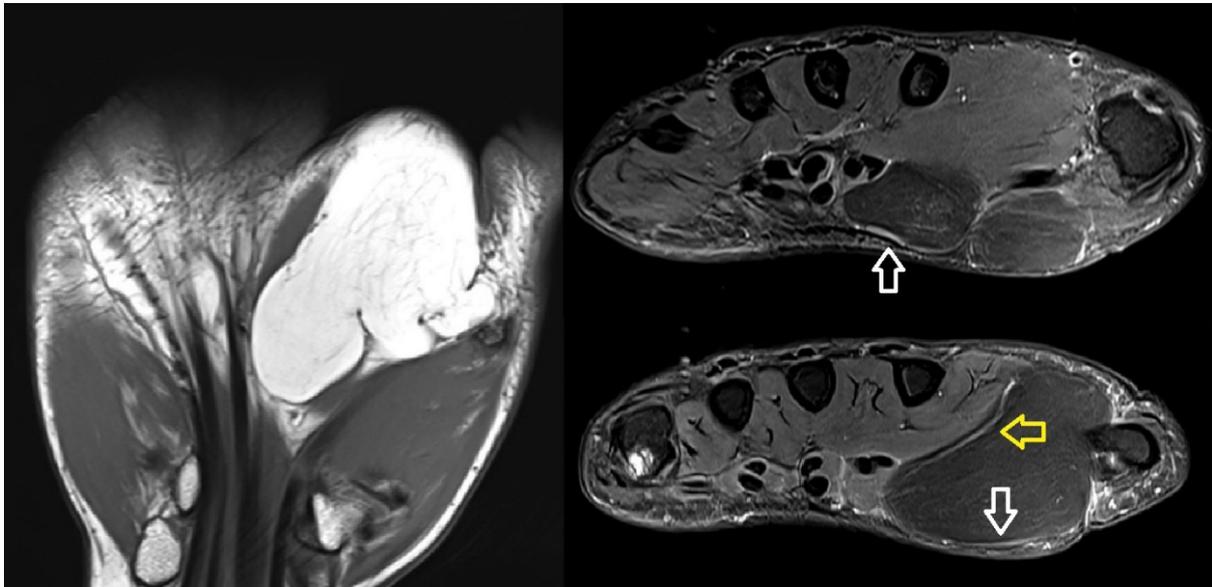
Preoperative MRI findings. A 6×4×3 cm tumor, appearing as a lipoma, is situated on the radial side of the palm. The tumor is located between the ulnar digital nerve (yellow arrow) and the radial digital nerve (white arrow) of the thumb.
